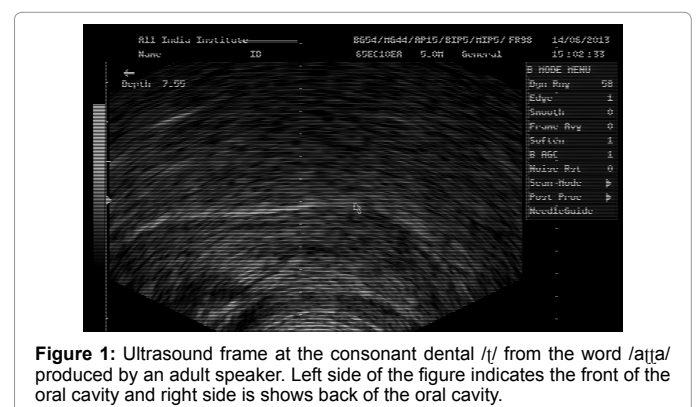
Ultrasound frame at the consonant dental /t/ from the word /att̪a/ produced by an adult speaker. Left side of the figure indicates the front of the oral cavity and right side is shows back of the oral cavity.
